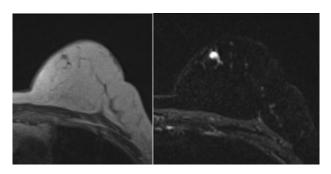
T1-weighted image showing a hypointense lesion (left) with associated marked T2 signal hyperintensity (right).
